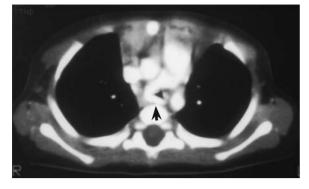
Anomalous left pulmonary artery. CT with intravenous contrast medium shows the anomalous left pulmonary artery originating from the right main pulmonary artery, passing posterior to the trachea between the airway and the esophagus (*arrowhead*)
